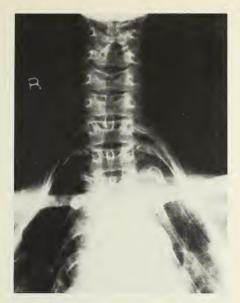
Radiograph of "giraffe" woman who had the heavy rings removed to treat an illness.
